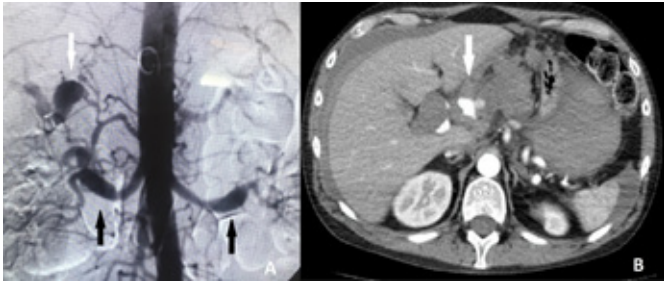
(A) Digital subtraction angiography (DSA) of case 1 showing the aneurysm of the right hepatic artery (white arrow) as well as aneurysm of both renal arteries (black arrows). (B) Computed tomography angiography (CTA) of the same patient showing the ruptured aneurysm with the perianeurismal hematoma. (arrow)
